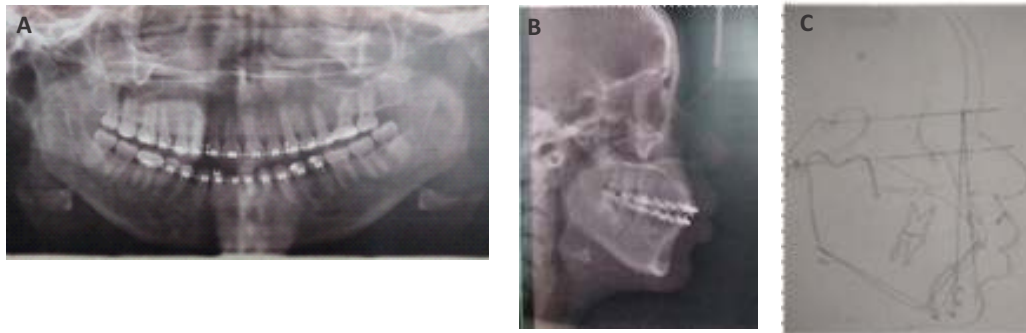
(A) Post-treatment panoramic radiograph; (B) cephalogram; and (C) Tracing
